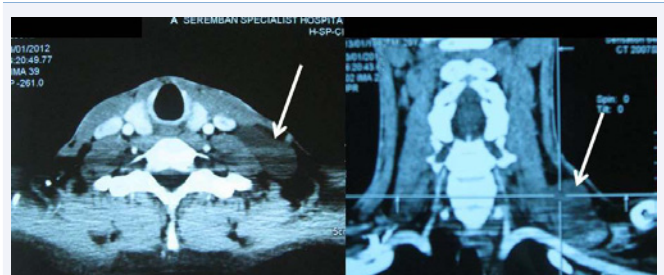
(A) Axial and (B) Coronal computed tomography scan of the neck showed a 6.0 cm x 5.0 cm x 3.0 cm well-defined hypo dense lesion in the left supraclavicular region.
